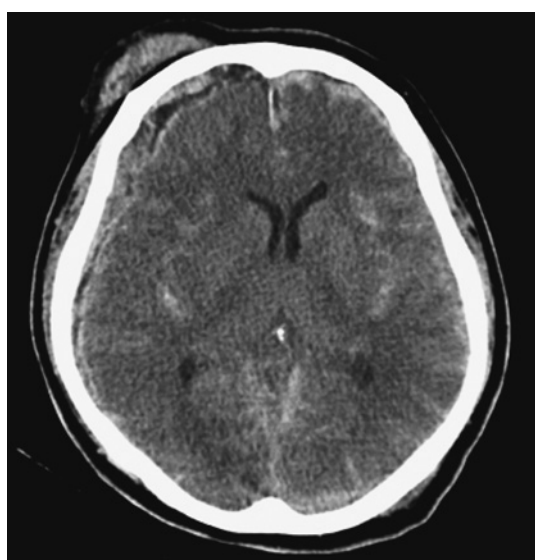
Cranial computed tomography scan showing acute subdural hematoma with a midline shift and brain contusions.
